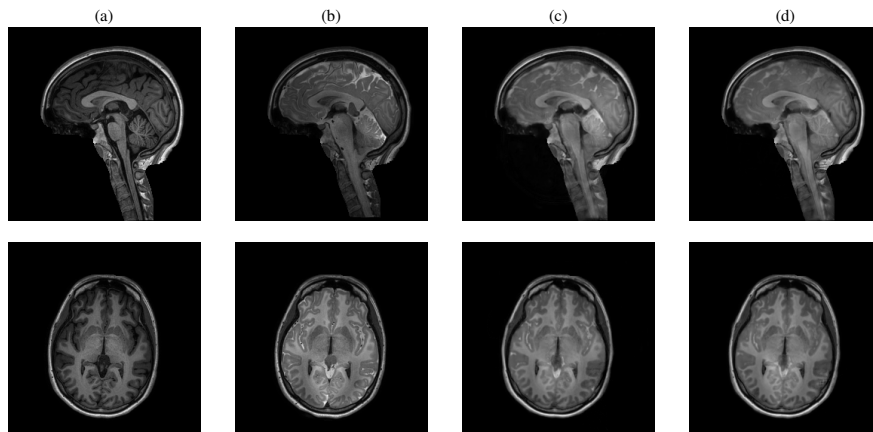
A sample test case (sagittal and axial plane) of gadobutrol distribution prediction based from baseline MRI scans (pre-injection). 5a: real MR imaging taken before injection. 5b: real MR imaging taken approximately 24 hours after intrathecal tracer injection. 5c: predicted tracer distribution 24 hours post-injection using an ℓ_2 loss function. 5d: predicted tracer distribution using an ℓ_1 loss function.
